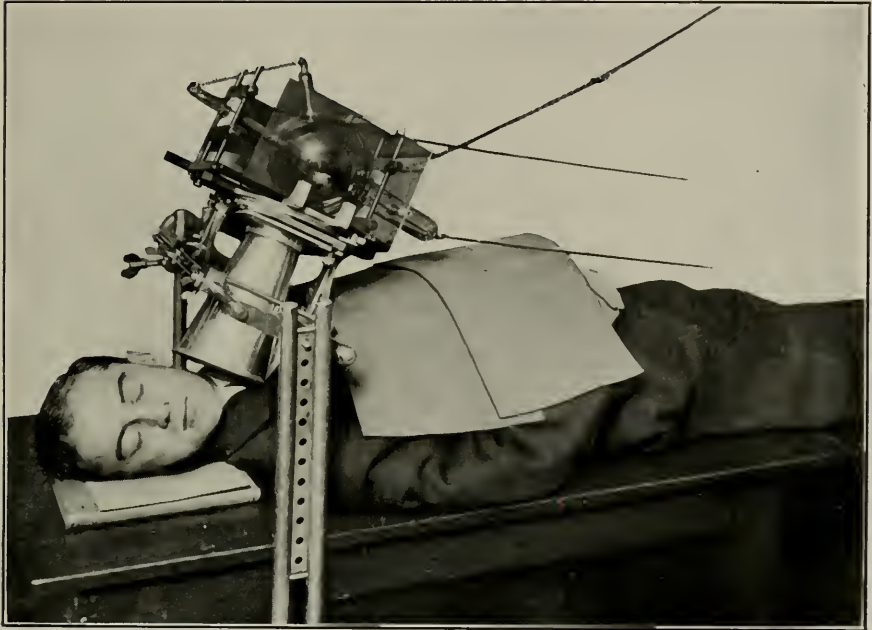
Pose for the radiograph shown in Fig. 100.
